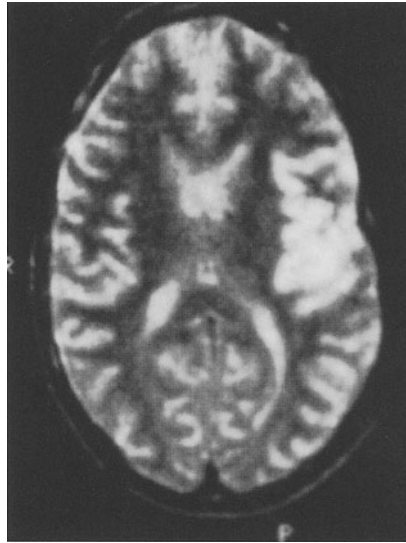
T2-weighted open-design, low-field MRI demonstrating marked abnormal signal intensity in the left medial temporal lobe. High-field MR interpreted as normal. (Image from a 0.64-T Toshiba open MR system)
